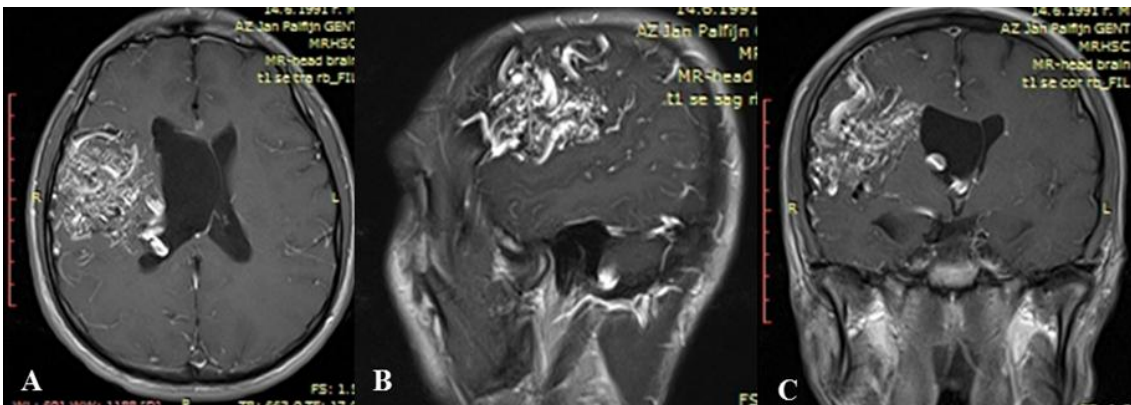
MRI images of AVM:
